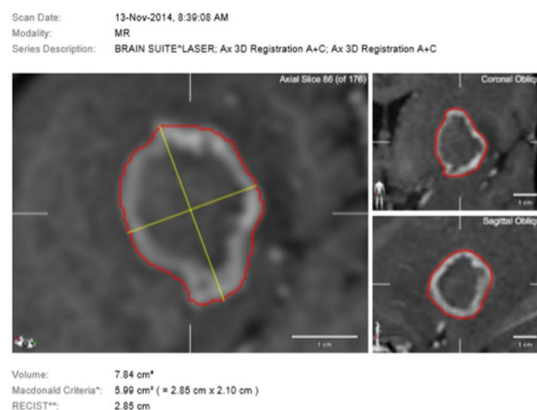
Lesion dimensional measurement. Dimensional measurement using BrainLAB Elements software through definitions of lesion limits in axial, coronal, and sagittal incidences. *2 dimensional tumor criteria for gadolinium-enhancing T1-weighted lesions. Response
